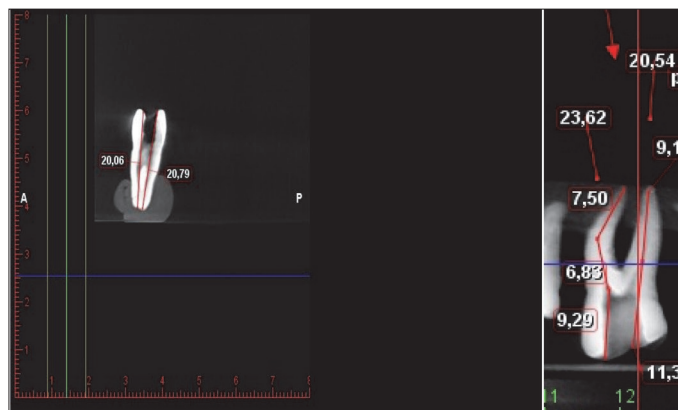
Connecting the apical foramen and reference point with one straight line and multiple segmented lines on a CBCT cross-section
